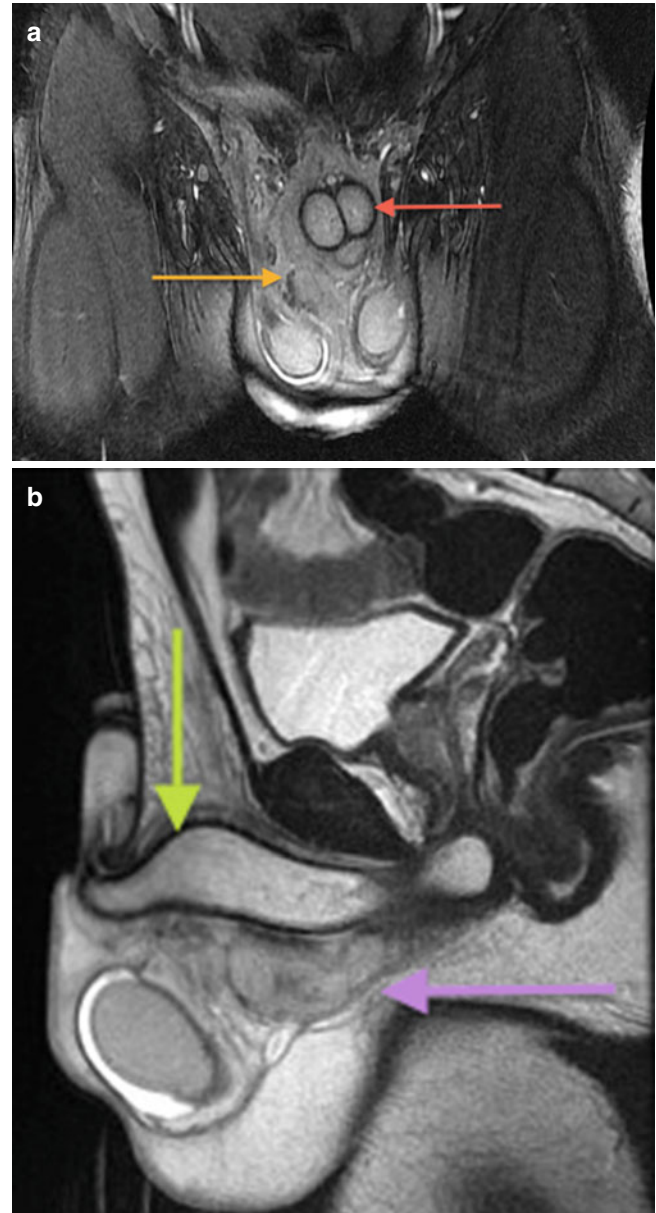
Coronal (a) and sagittal (b) T2-weighted, fat-saturated MRI sequences demonstrate a mixed-signal collection inferior to the penile shaft (orange arrow in (a), purple arrow in (b)) compatible with a hematoma. The low-signal tunica albuginea is well visualized and is intact (red arrow in (a), green arrow in (b))
